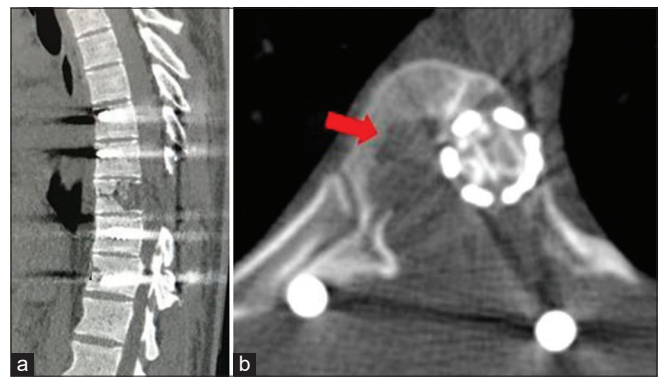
Computed tomography of the spine at the 5th month. (a) Sagittal section showing recurrence of lytic lesion at T9 vertebra with spinal stabilization. (b) Axial section showing lytic lesion at the right side of T9 vertebral body (marked with arrow) and cage with bone growth at previous left side lesion.
